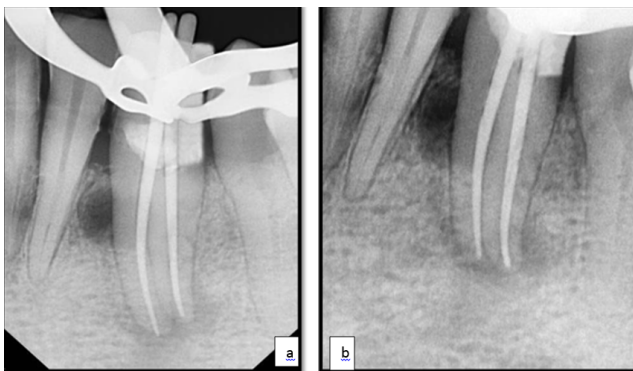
Radiograph showing root canals obturated with gutta percha and post endodontic restorations coronally wrt #43.
